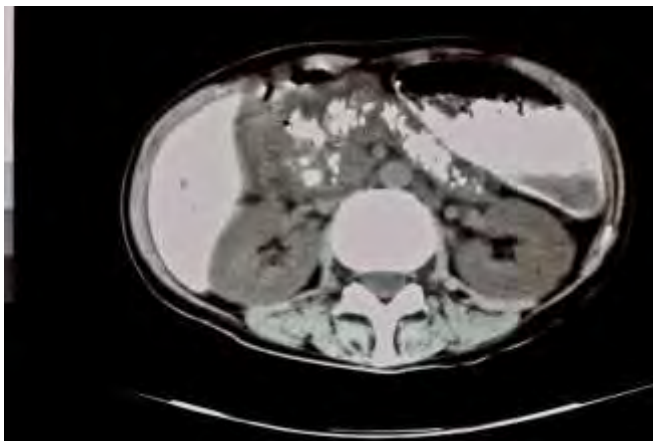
Computed tomography scan of the upper abdomen in patient SW with unsuspected primary hemochromatosis before treatment, October 1992. Reproduced from 1995 paper in Clin Drug Invest³⁸⁶ (Springer).
